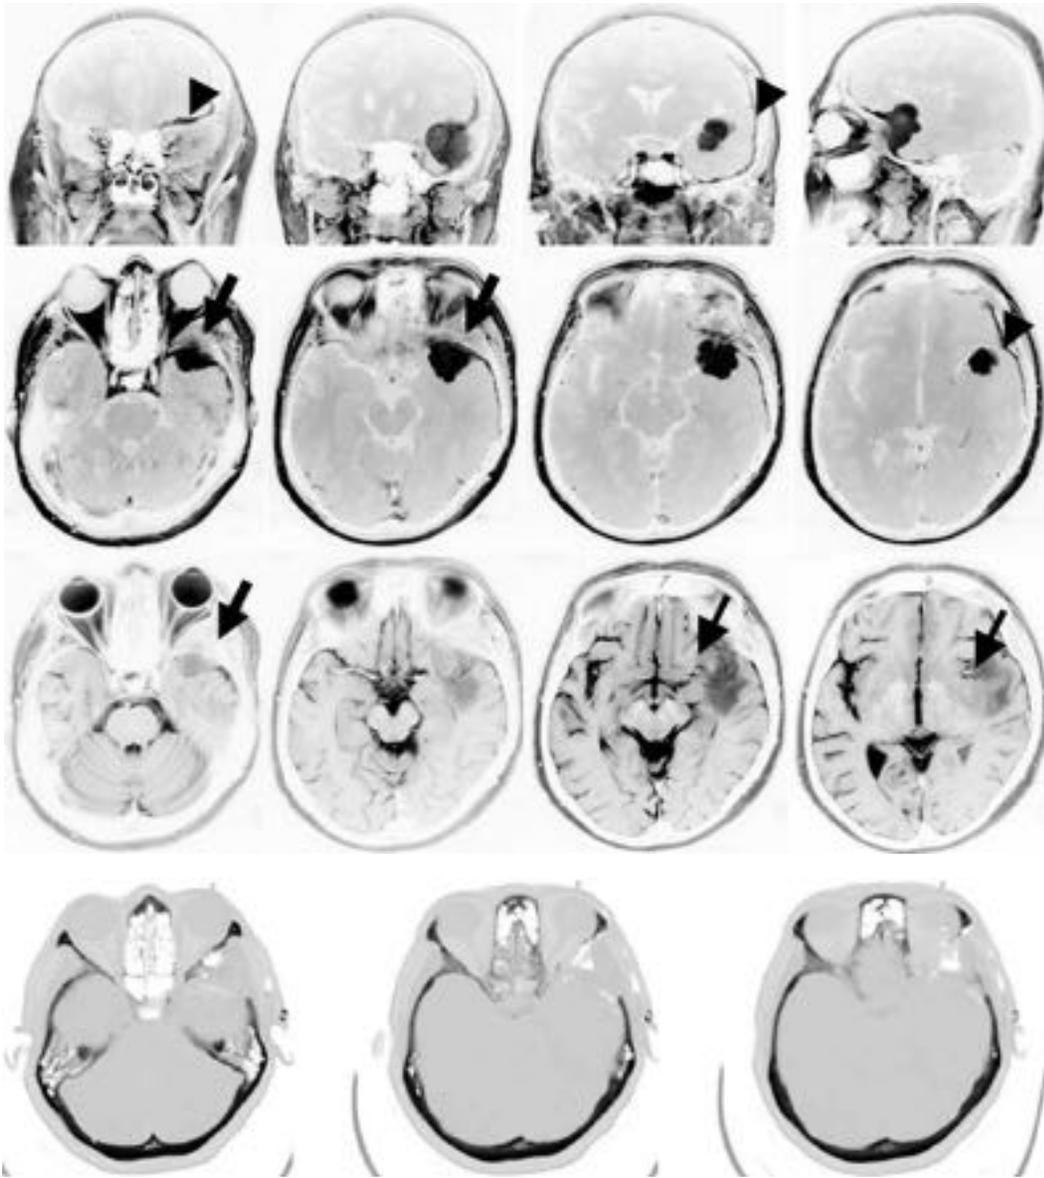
A medium-sized meningioma of the left middle sphenoid wing with extensive dural involvement and intraosseous growth. The tumor was diagnosed in a 73-year-old woman following several seizures. The ophthalmological exam was normal. (A) T1-weighted contrast-enhanced magnetic resonance imaging (MRI) scans showing the origin and size of the tumor (upper and middle row). There is extensive carpetlike involvement of the frontotemporal dura (*arrowheads*). The course of the middle cerebral artery and the M2 branches (*thin arrows*) are nicely depicted on T2-weighted images (lower row). At surgery, the vessels could be easily identified and preserved (see Fig. 23.9). Intraosseous growth is already apparent on the MRI scans (*arrows*). Involvement of the lateral orbital wall has resulted in mild exophthalmos. Dural and intraosseous tumor spread will sooner or later lead to optic nerve compression even before MRI will show a definite tumor mass (for comparison see Fig. 23.3: tumor mass encroaching upon the optic apparatus). (B) Postoperative computed tomographic scans depicting the extent of the bony resection. Copyright M. Simon and J. Schramm, reproduced with permission.
